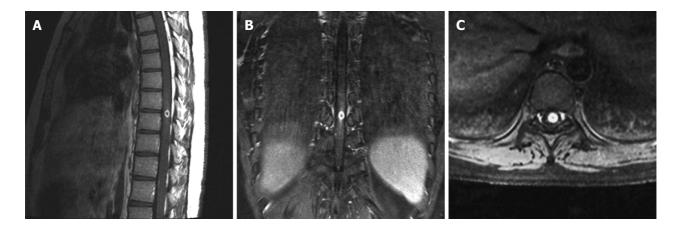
Magnetic resonance imaging examination before the operation showing a ring-enhanced intramedullary cord lesion at T8-T9. A: Sagittal image; B: Coronal image; C: Axial image.
